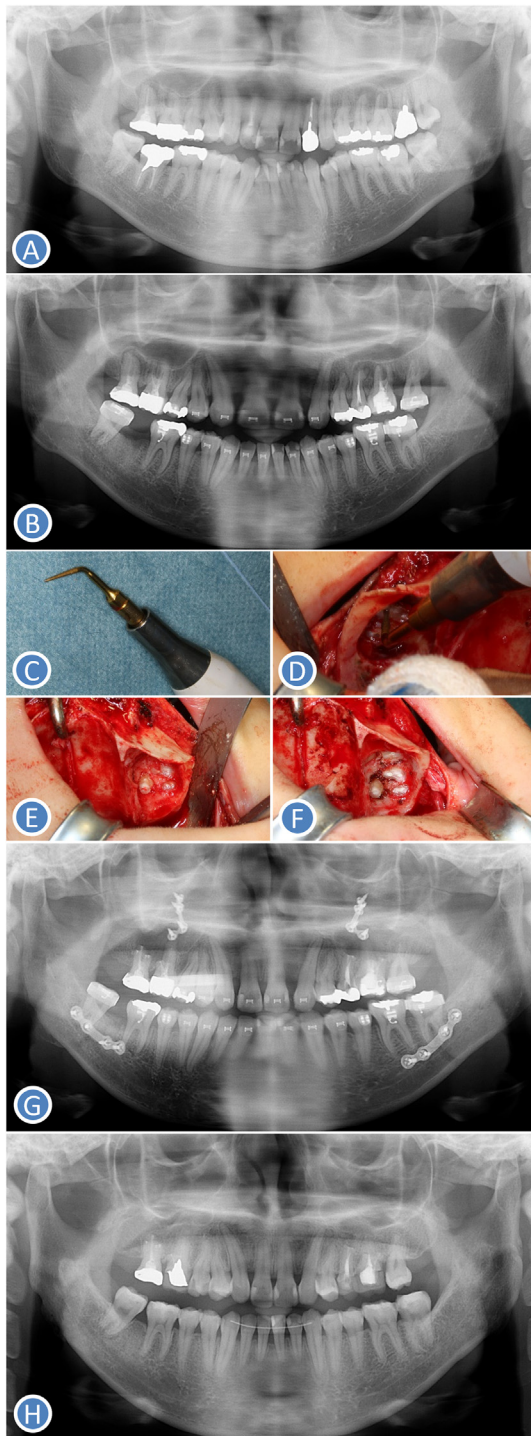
(A) Panoramic radiograph at the initial visit, (B) Preoperative panoramic radiograph, (C) Piezoelectric surgical device (Piezosurgery with OP5 tip), (D) Intraoperative view (Root-end preparation with piezosurgery of the left maxillary second premolar and first molar), (E) Intraoperative view (Root-end preparation with piezosurgery of the right maxillary first and second molars), (F) Intraoperative view (Root-end filling of the right maxillary first and second molars), (G) Panoramic radiograph immediate after orthognathic surgery, (H) Panoramic radiograph 2 years after orthognathic surgery.
